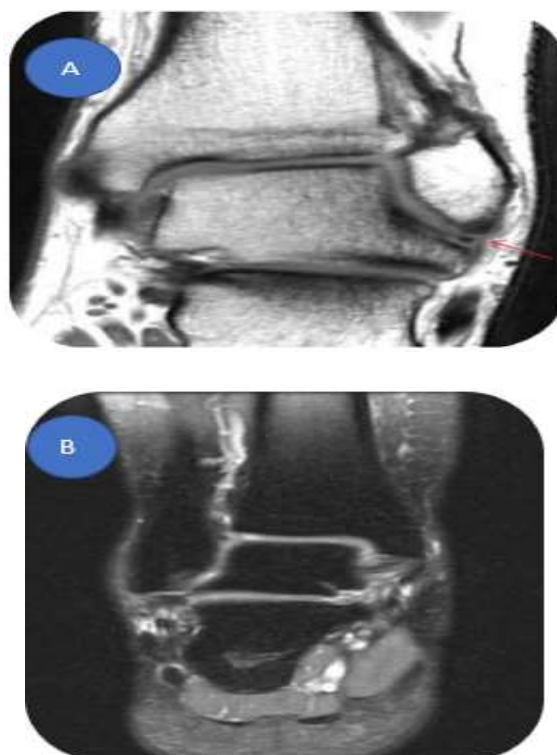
A - Coronal T1-weighted MR image showing an ATFL tear, B - Deltoid Partial Tear of the patients having age of 34 years
